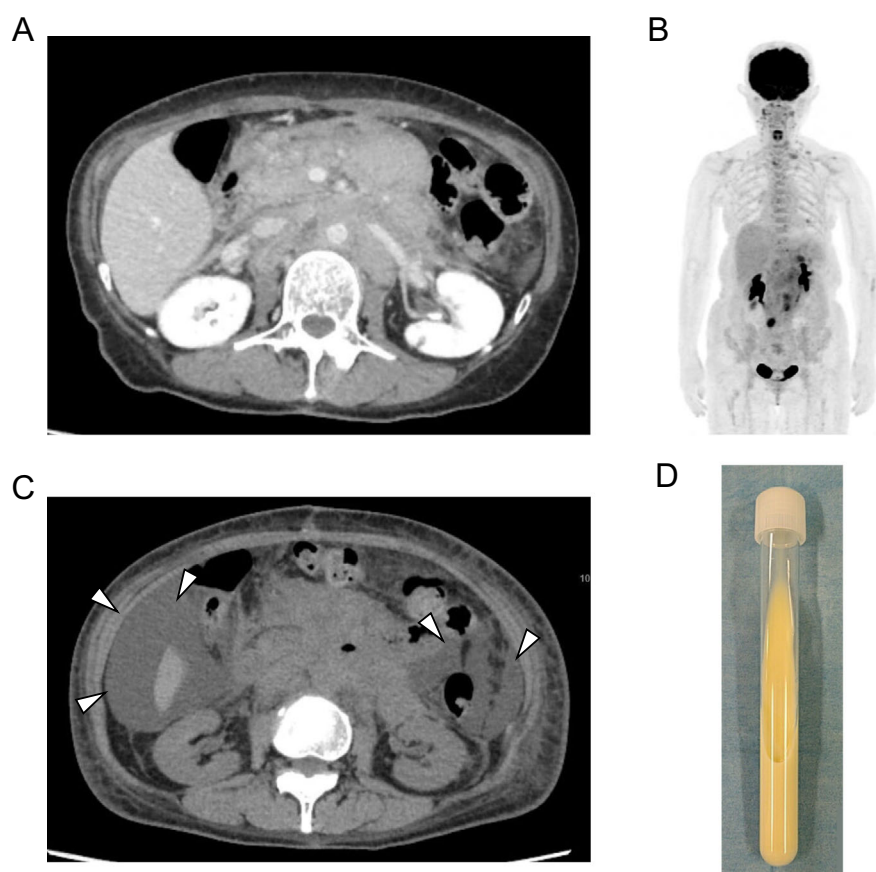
Patient presentation. (A) Computed tomography (CT) on admission. A large retroperitoneal tumor was seen in the abdomen. Ascites was not observed. (B) Positron emission tomography showed abnormal accumulation with SUV_{max} of 10.5 in the abdomen. (C) CT after the diagnosis of FL, showing an increase of ascites (arrowheads). (D) Paracentesis revealed yellowish ascites.
